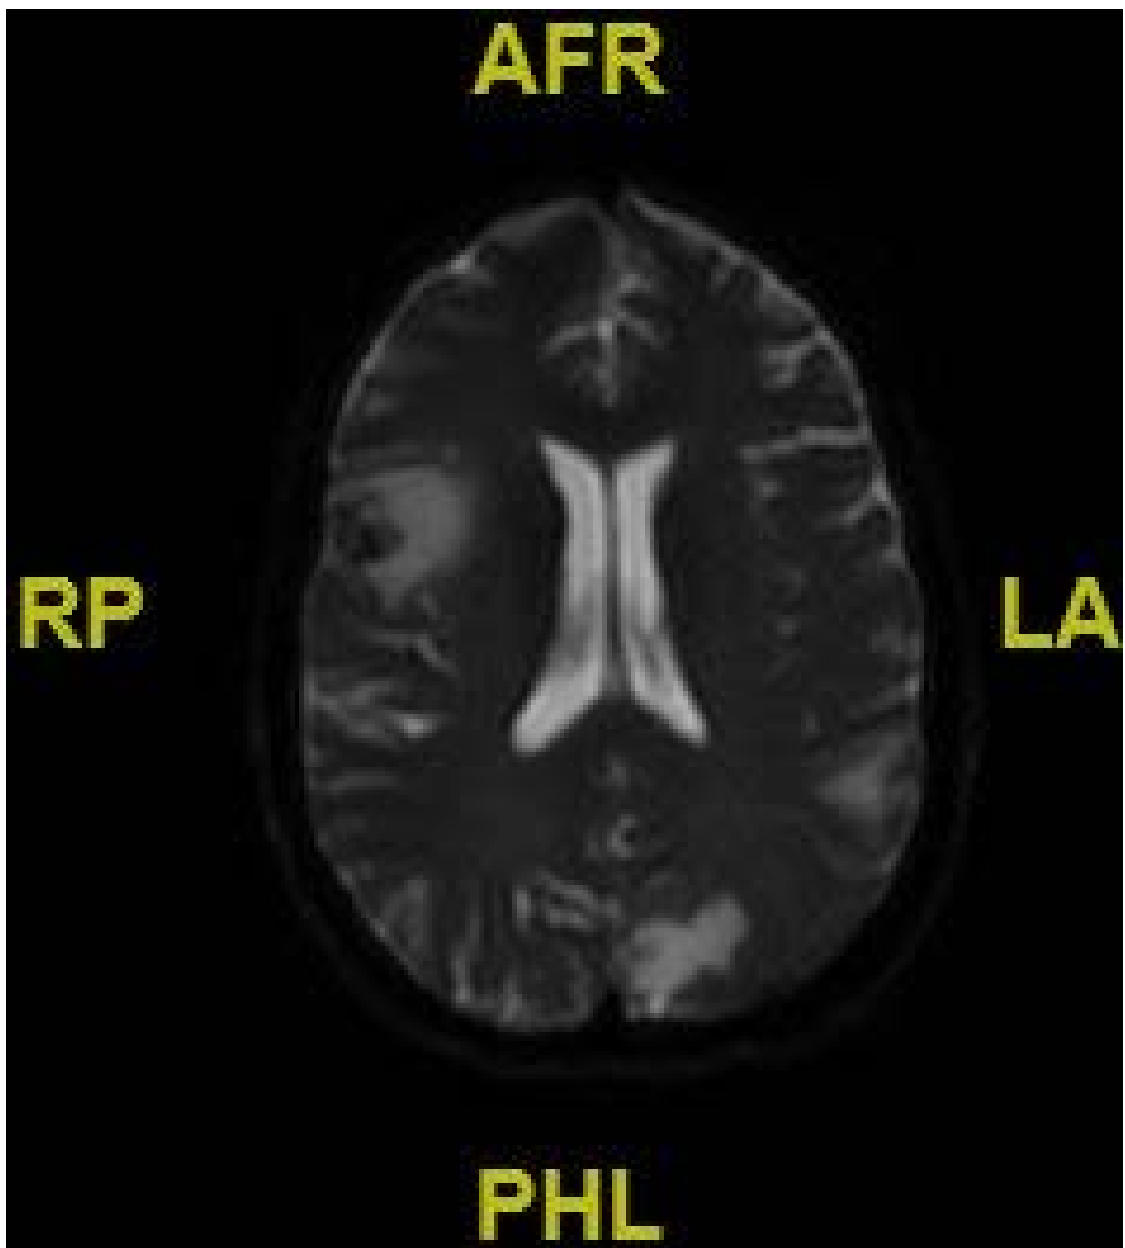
Cross-sectional brain MRI without contrast showing multiple abscesses in cerebral hemispheres, most notably in right parietal lobe.
